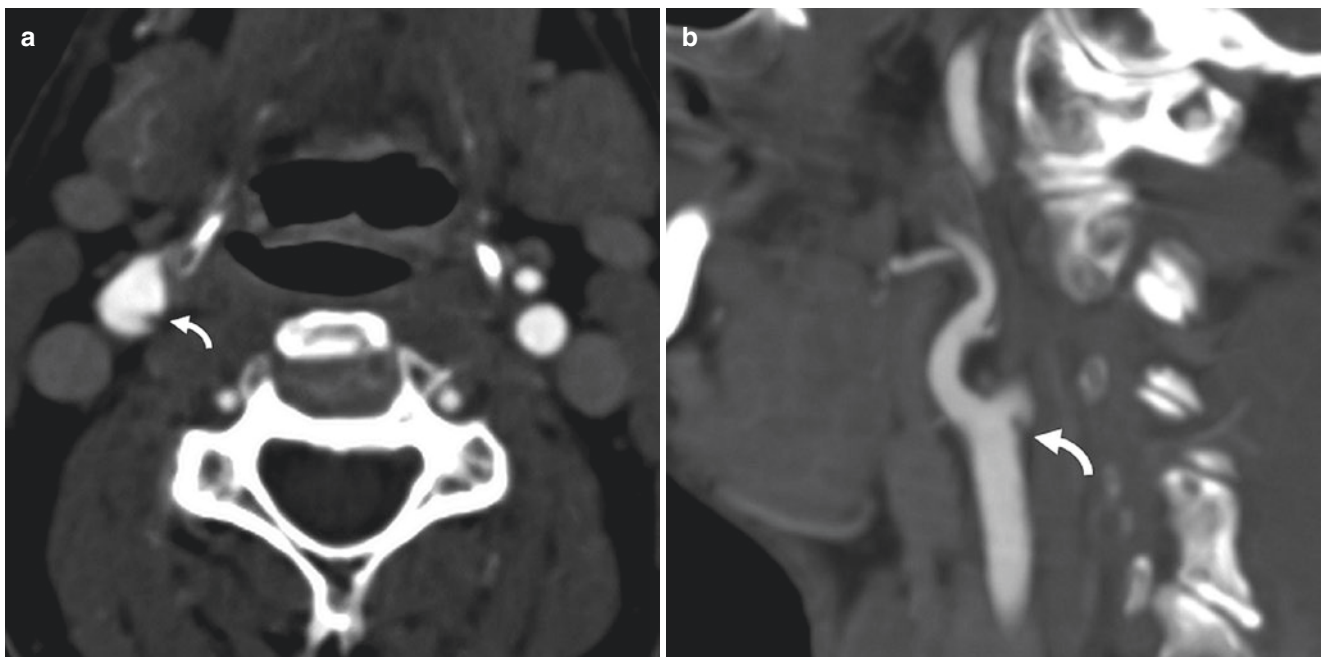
Carotid web mimicking dissection flap. Axial (a) and sagittal (b) CTA shows a linear filling defect at the carotid bulb posteriorly consistent with carotid web
